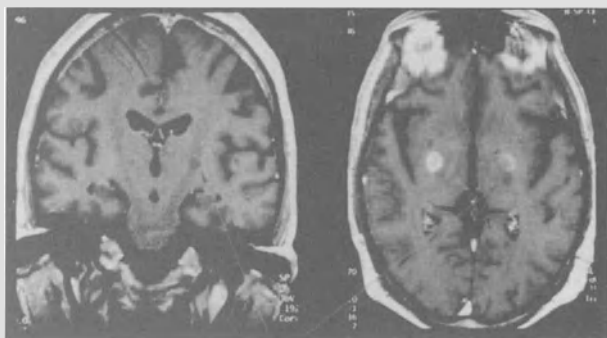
Coronal and axial MRI scans performed 13 days after a second left-sided pallidotomy. Arrows indicate an infarction in the internal capsule, just posterior and ventral to the left-sided pallidotomy lesion
